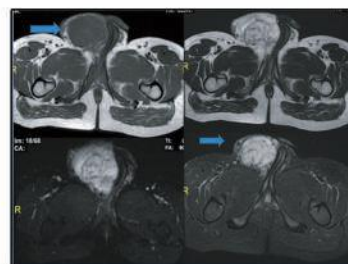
A, B, C and D: MRI T1W, T2W, STIR and DWI axial images of inguinoscrotal region reveal a large T2W/STIR heterogeneously hyperintense lesion with restriction of diffusion on right side. Lesion is hypointense on T1W with multiple hyperintense areas (hemorrhage). Lesion is seen extending proximally along the spermatic cord / tunica vaginalis. Left testis is compressed and pushed laterally.
